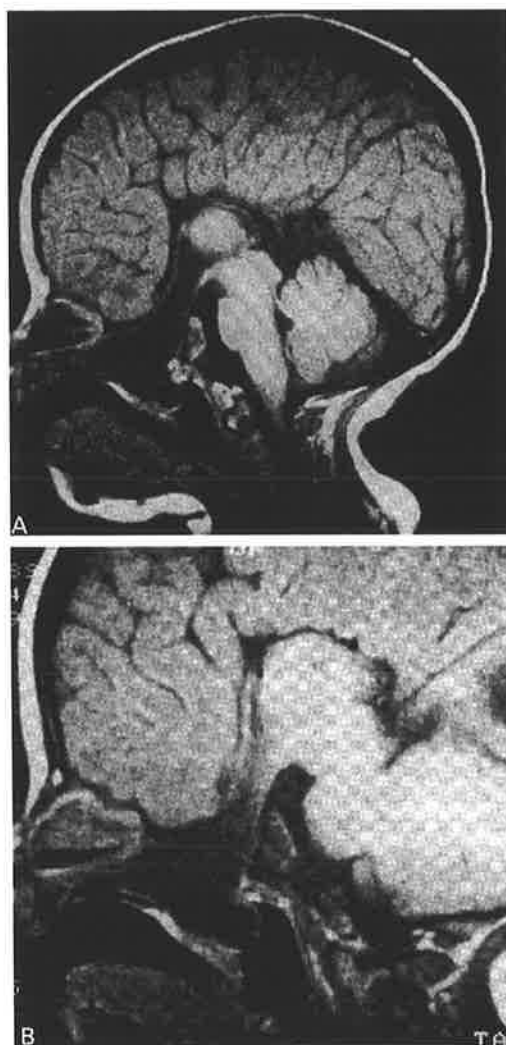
A. B. MRI scan of four month old child with a sphenothmoidal meningo-encephalocele, sagittal views
